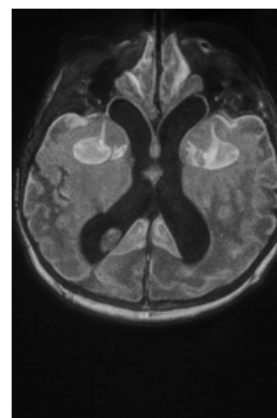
An MRI showed periventricular leukomalacia due to hypoxic ischemic encephalopathy.
